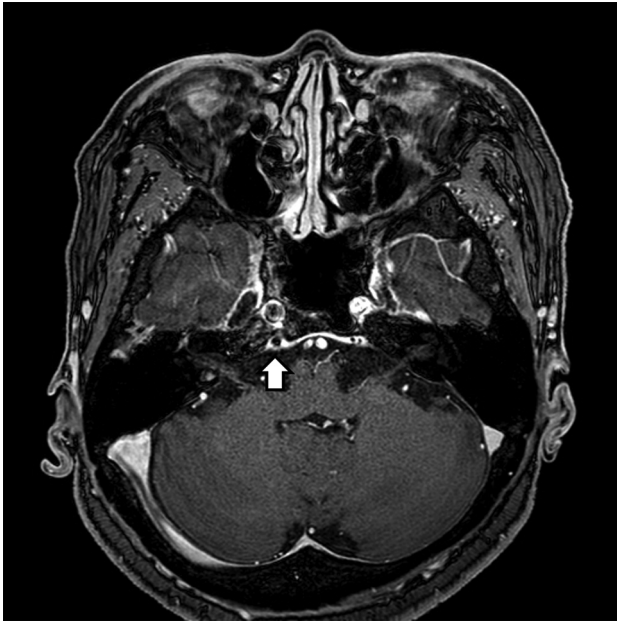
A CCF case with prominent venous drainage flow in the posterior venous structure. Axial contrast-enhanced T1-weighted image of a patient with diplopia, confirmed to be right sixth cranial nerve palsy on neurologic examination. Note the enlarged right inferior petrosal sinus (posterior) with an internal signal void (*arrow*) indicating increased flow rate. The patient was confirmed as having an indirect CCF on digital subtraction angiography.
